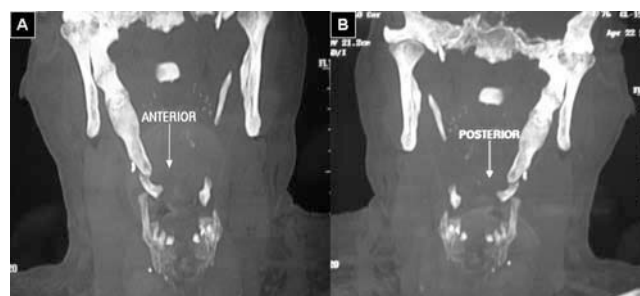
A and B. Coronal cut of computed tomography scan (anterior and posterior views), showing the ossification of the right stylohyoid ligaments.
